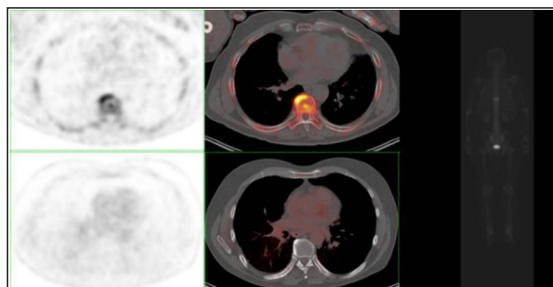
The patient with stable metastatic lung carcinoma in the T8-9 vertebral region with mild fluorodeoxyglucose (FDG) uptake but significant activity accumulation in the sclerotic lesion in sodium fluoride positron emission tomography/computed tomography (NaF PET/CT) images.
